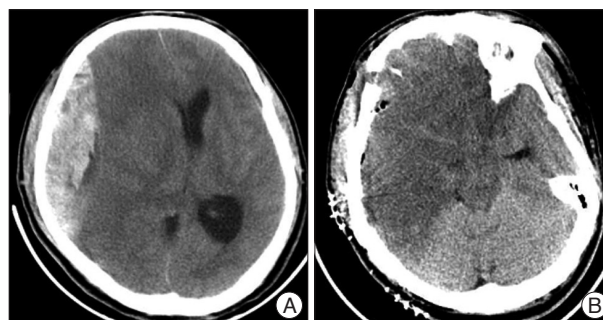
A : Computerized tomography (CT) showing an acute epidural hematoma with a midline shift, B : postoperative CT showing a multi-territory infarction including middle cerebral artery distribution.
